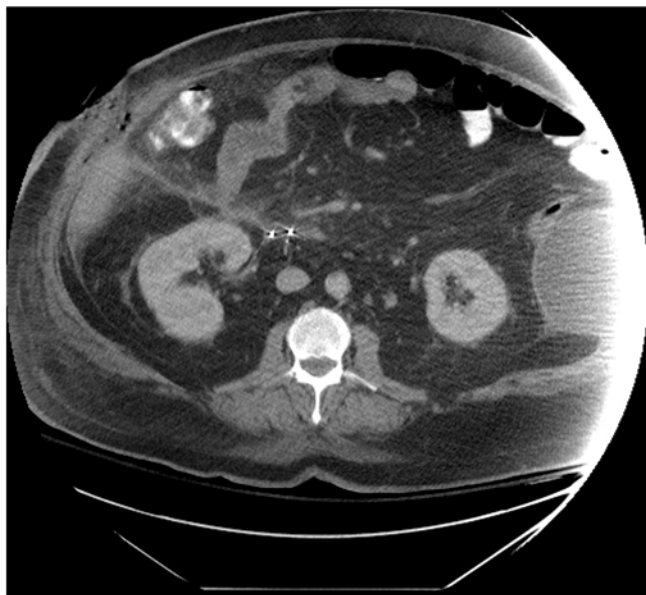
CT scan of pancreatic fistula with communication from the retroperitoneum close to pancreatico-jejunosomy site.
